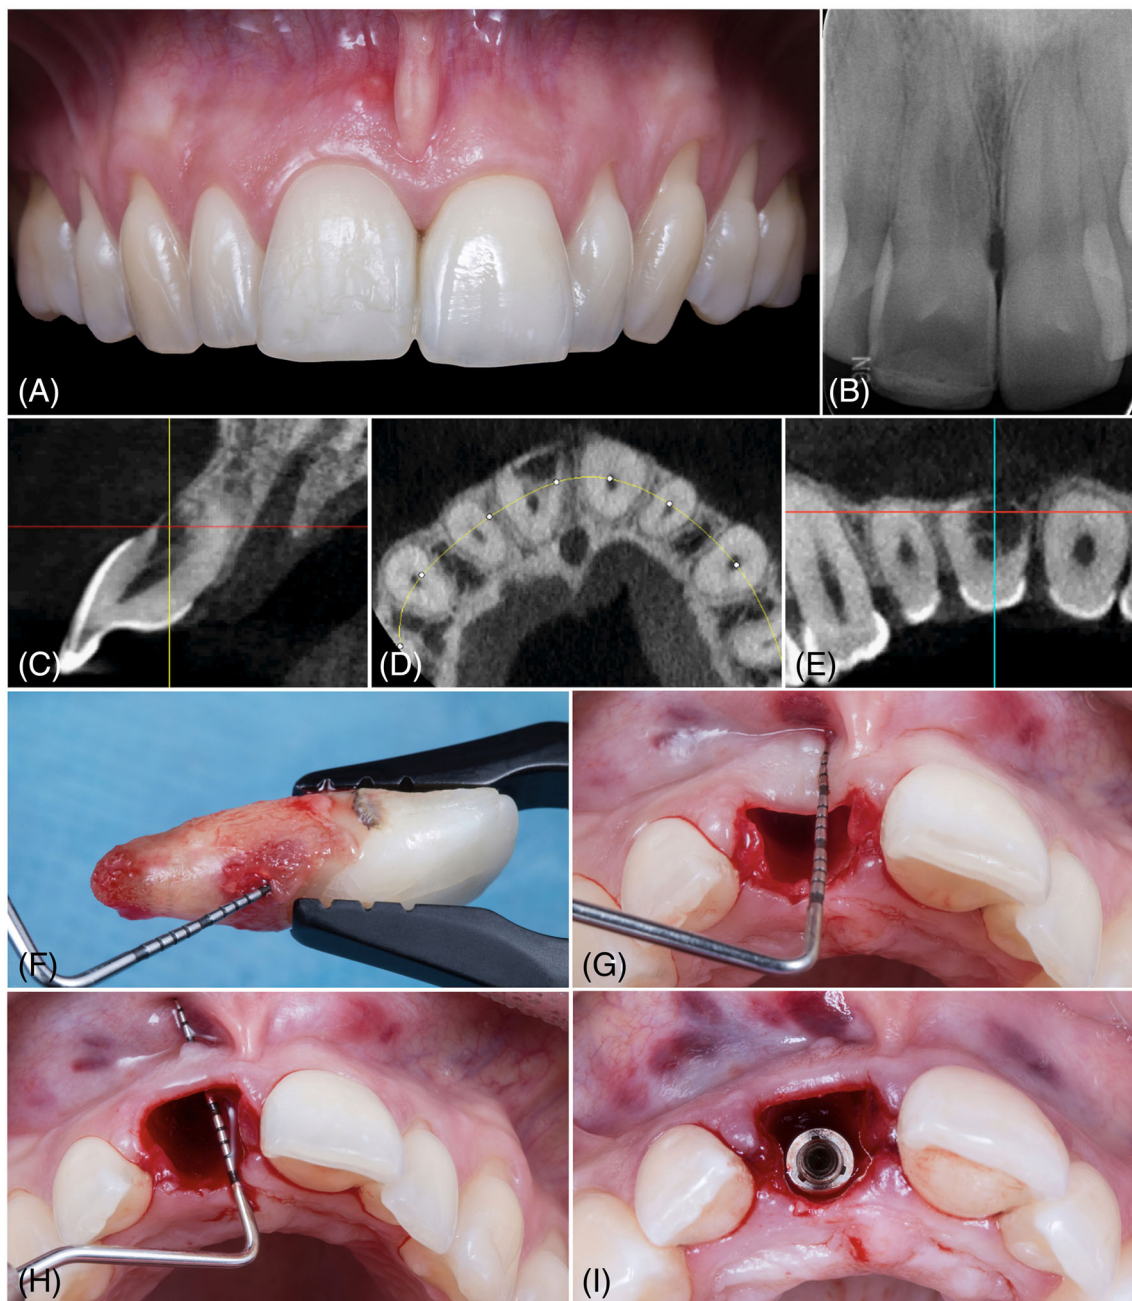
Immediate implant placement into type II extraction socket. (A) Clinical examination showed a 12-mm probing depth and a sinus tract in the mucogingival junction of the maxillary right central incisor (tooth 11). (B) Radiolucent image in the cervical and middle third of tooth 11 compatible with an external resorption. (C–E) Small volume cone beam computed tomography (CBCT) images confirmed a total loss of buccal bone wall associated with the buccal and mesial position of the external resorption. (F) Extraction of the affected tooth where the extension of the external resorption can be observed. (G) Absence of buccal bone wall confirmed after extraction. (H) Periodontal probe through the sinus tract after removal of infected tissue. (I) Immediate implant placement (13 mm × 3.8 mm, Camlog Screw Line; Camlog Biotechnologies, Wimsheim, Germany): the implant was anchored in palatal bone and 3 mm apical to the gingival margin
